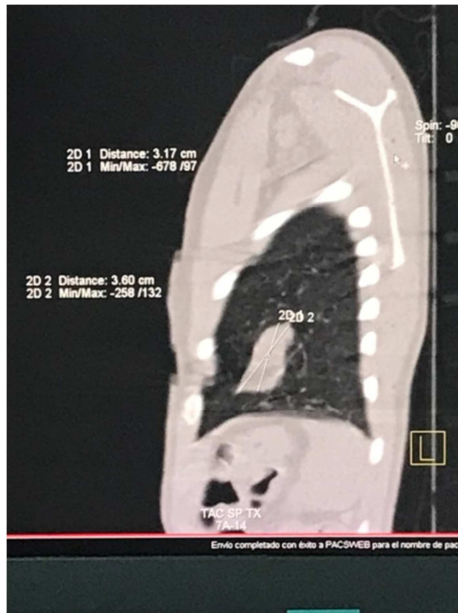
Contrast-enhanced CT scan of the chest sagittal view, where a metastatic lesion of the lower lobe of the left lung is displayed.
